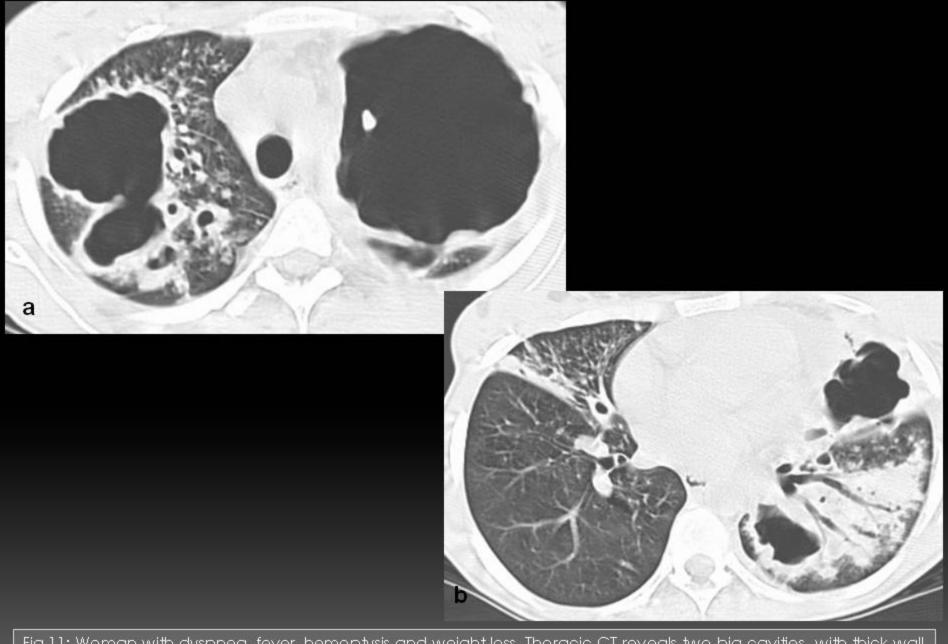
Woman with dyspnea, fever, hemoptysis and weight loss. Thoracic CT reveals two big cavities with thick wall in the upper lobes (a), tree-in-bud and ill-defined micronodules in the middle lobe, cavitations and consolidation with air broncogram in the left lower lobe (b). Sputum analysis positive for M. tuberculosis.
